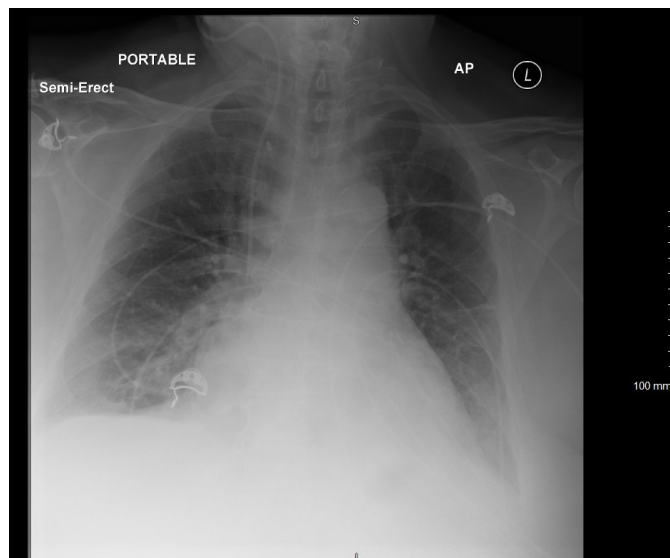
Chest X-ray at the time of admission showing a left lower lobe infiltrate.
